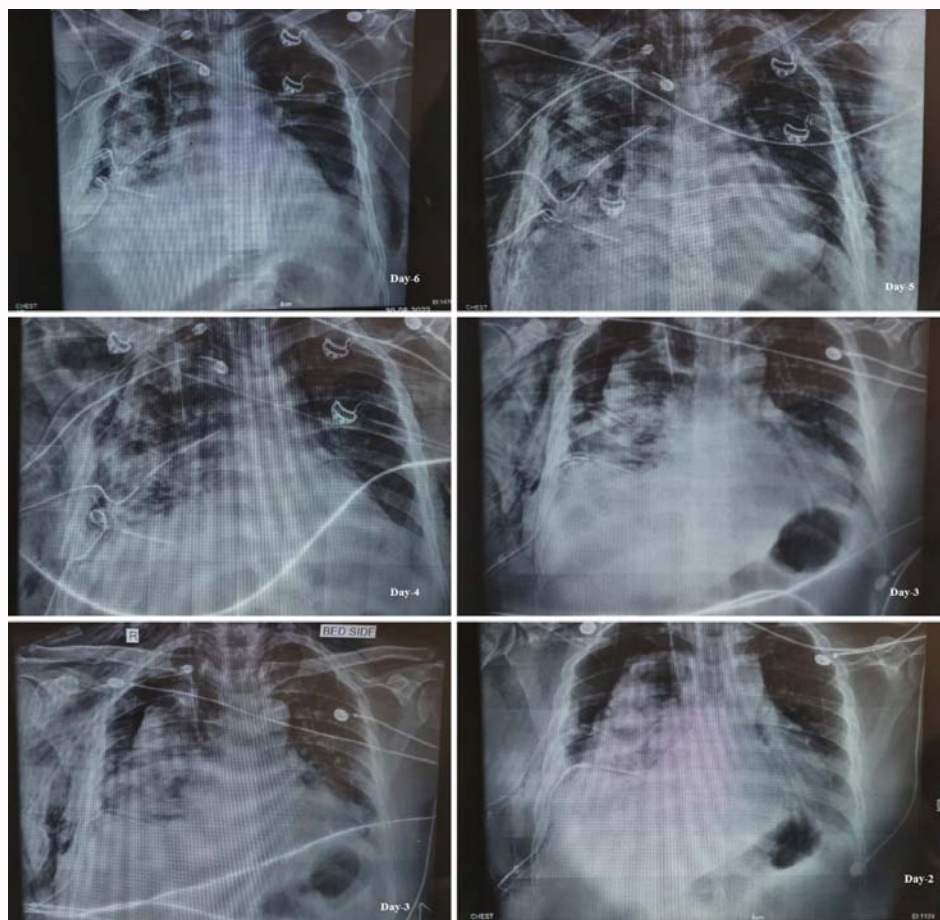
Chest X-ray (shows the Variation in Pleural effusion, persistent air leak in Rt pleural space from Day 2 to 6, Rt mild chest wall deformity and scoliosis and S/o Pneumothorax).
